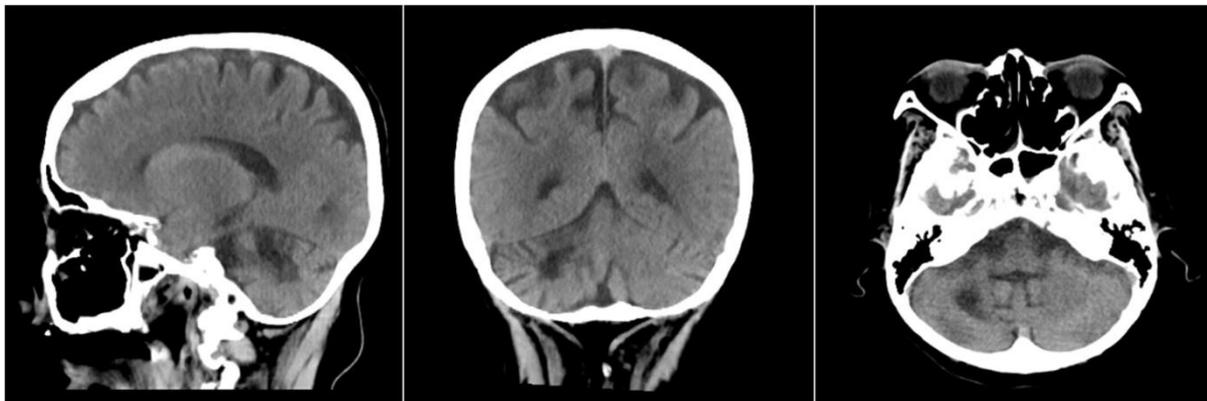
Non-Contrast Head CT Scan.
